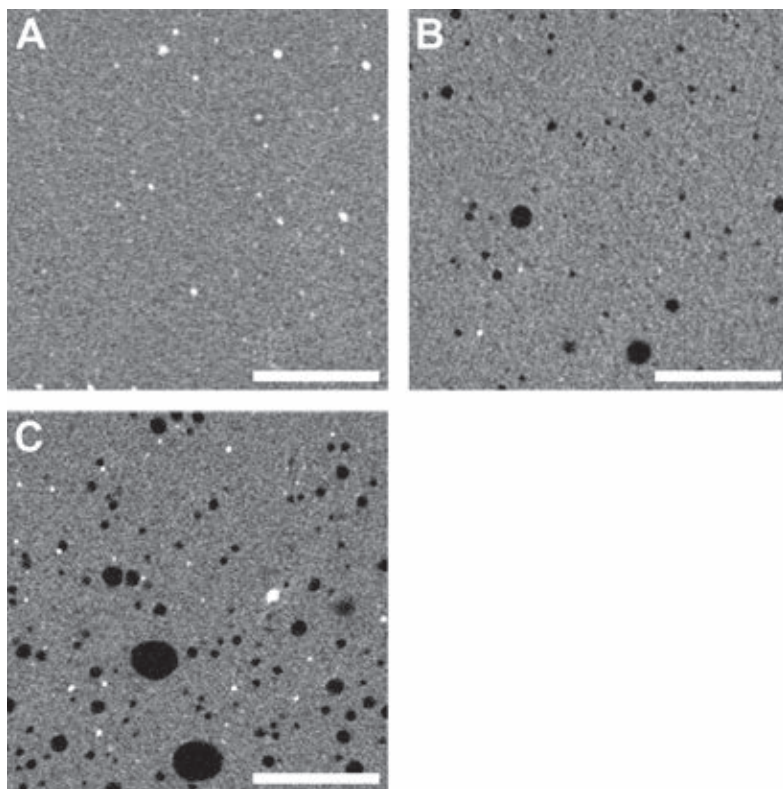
A) Representative micro-computed tomography slices of CMW-3 cured at 2.2 bar B), CMW-3 cured at atmospheric pressure, and C) the fractured cranioplasty. Pores are visualized in black and filler particles in white. Scale bar: 2 mm
